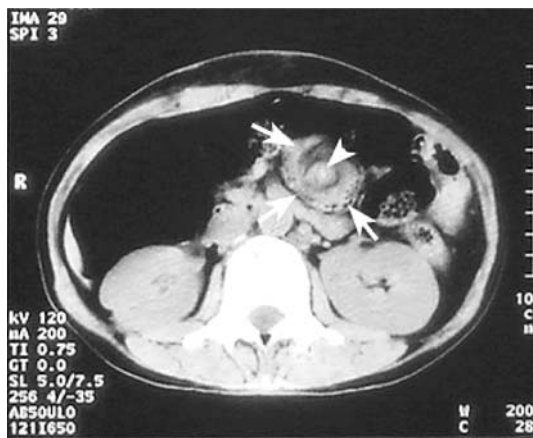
Computed tomography scan of the upper abdomen demonstrating the “whirling” pattern of jejunal loops (arrow) encircling the mesenteric vessels (arrowhead)
